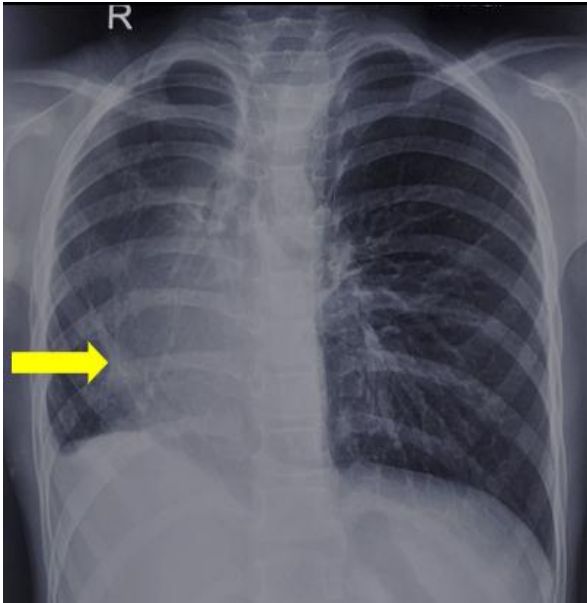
Chest X-ray PA view showing volume loss of right lung as evidenced by mediastinal shift towards right and rib crowding. Scimitar sign (arrow) is seen.
